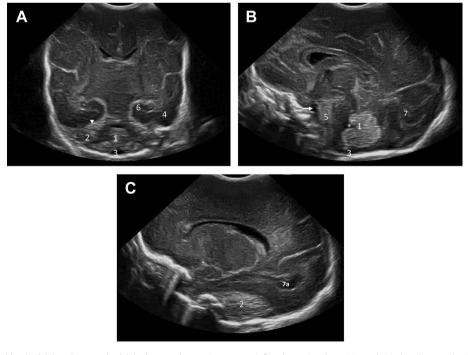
Normal coronal (A), midsagittal (B) and parasagittal (C) ultrasound scans in preterm infant (gestational age 28 weeks) using the anterior fontanel as acoustic window, showing cerebellar vermis (1) and hemispheres (2), cisterna magna (3), temporal lobe (4), pons (5), hippocampus (6), occipital lobe (7) with occipital horn (7a), fourth ventricle (asterisk), prepontine cistern (arrow) and area of tentorium (arrowhead).
